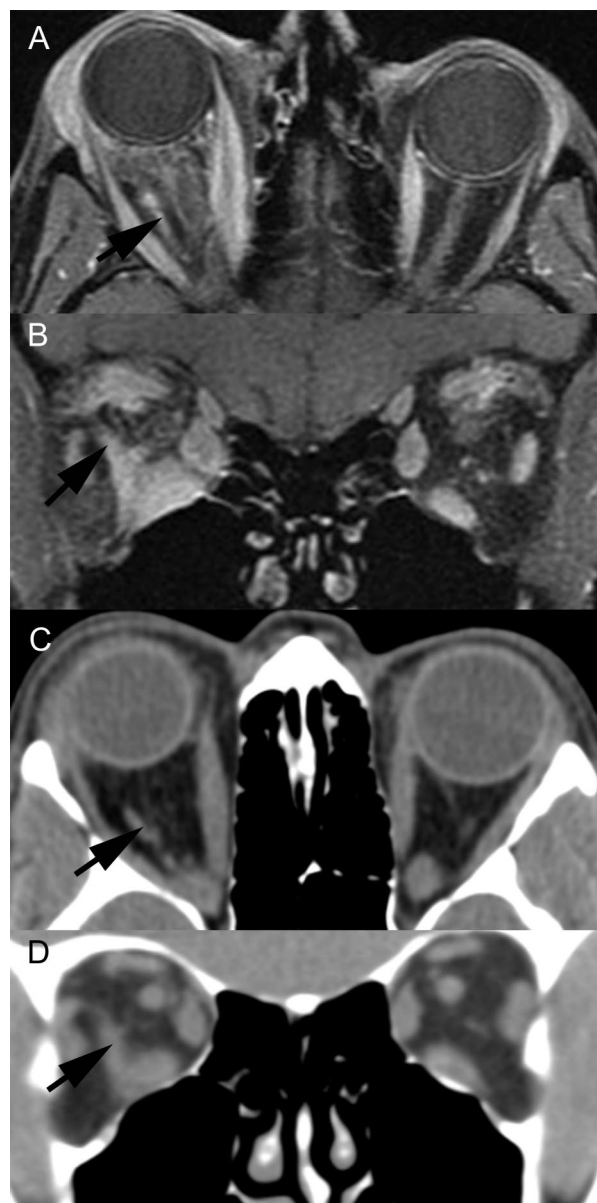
Pretreatment: axial (A) and coronal (B) T1 fat saturation postcontrast images. The extraocular structures enhance postcontrast. The accessory extraocular structure in the right orbit is shown (arrows). Posttreatment: axial (C) and coronal (D) CT images.
